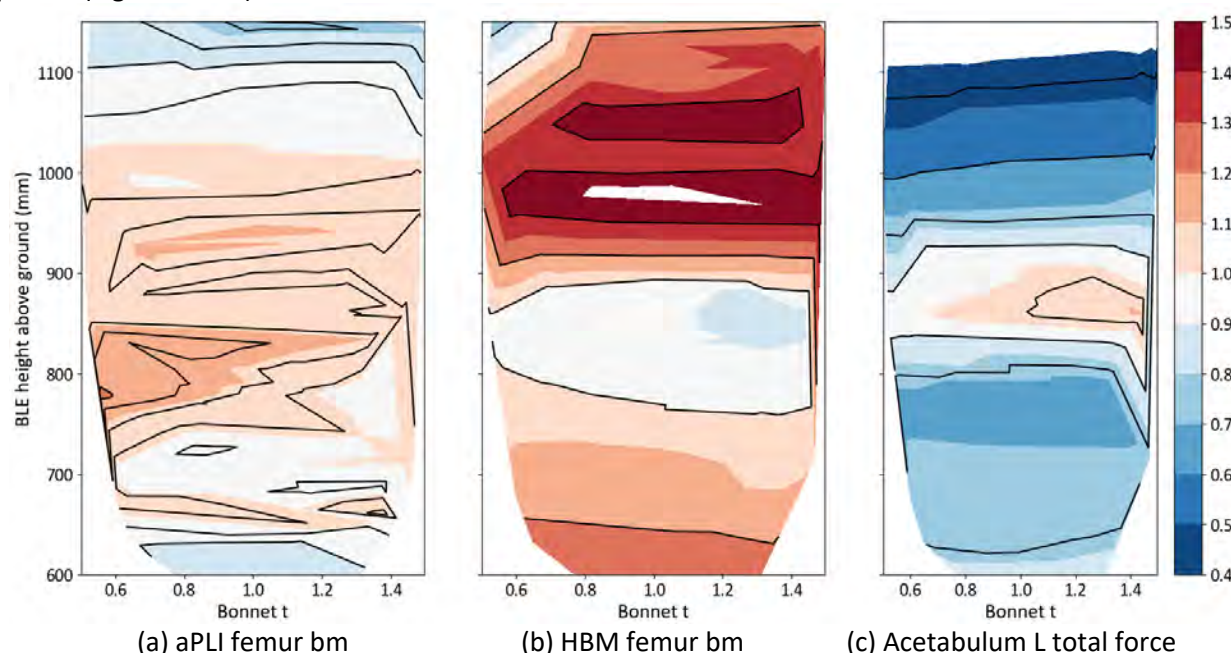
Normalised maximum injury values at test position Y0 for the SUV by varying the exterior sheet thickness of the bonnet and the shooting height of the impactor (converted to BLE height above ground).
